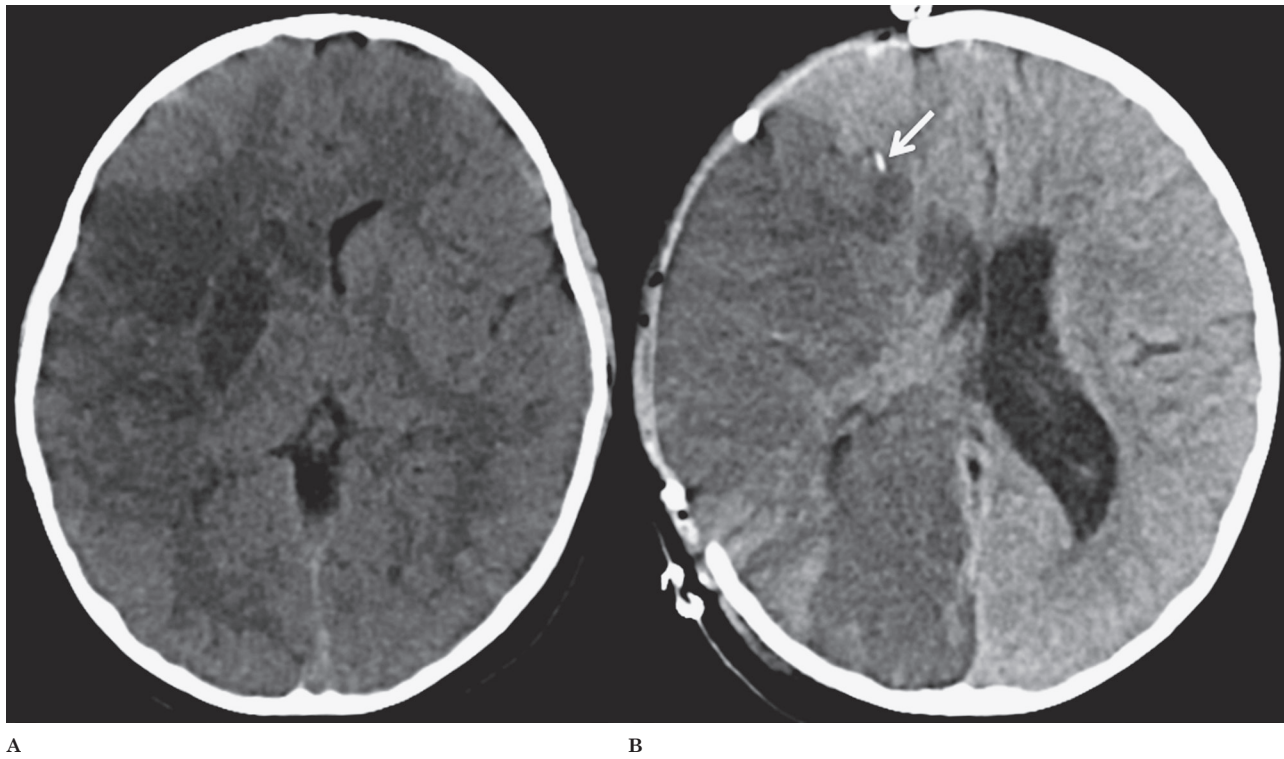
A) Follow-up axial CT 28 hours after onset of symptoms revealed a better delineation of the infarcted tissue as hypodensity in the right basal ganglia, anterior tip of the right temporal lobe and insula. B) Follow-up axial CT after hemicraniectomy showed evolving right MCA stroke with secondary involvement of the right PCA, moderate edema of the infarcted regions and mild right to left midline shift. The intracranial pressure monitoring device is noted as a hyperdense focus anterior to the body of the lateral ventricle within the right frontal lobe white matter (arrow).
